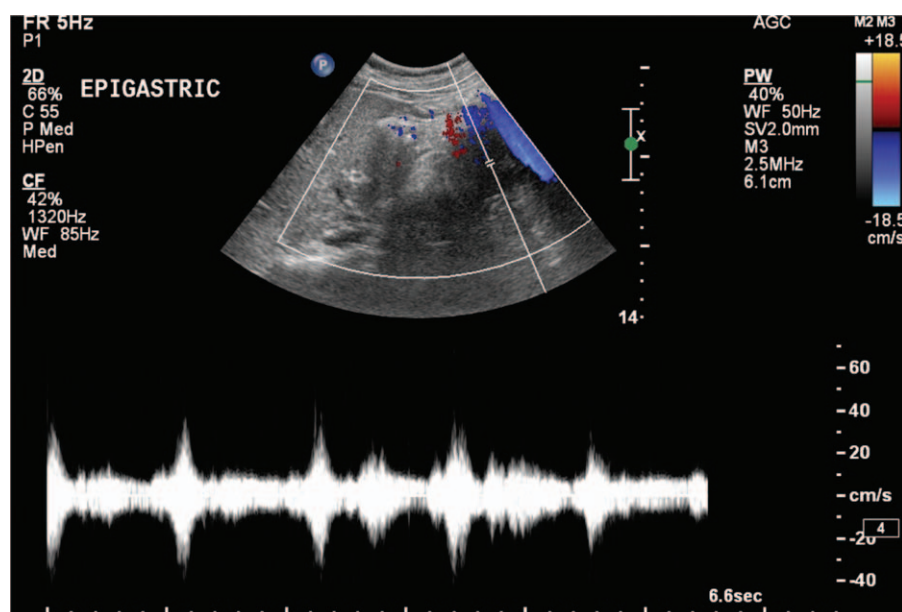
Abdominal ultrasound with Doppler studies reveals a strong arterial waveform in tracing on bottom of screen, indicating a vascular, arterial mass. Blue and red Doppler signals within the mass demonstrate turbulent (to-and-fro) blood flow.
